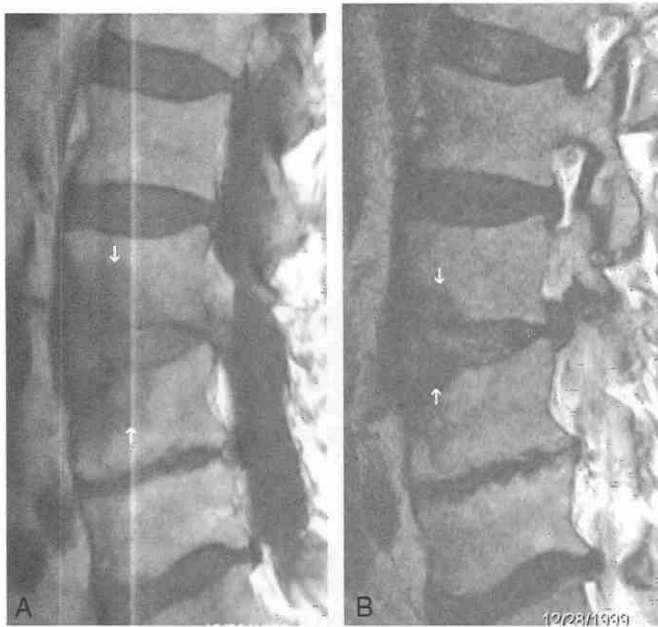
Type III end-plate changes. T1-weighted (A) and T2-weighted (B) MR images show hypointensity of the inferior L3 and superior L4 end plates on both sequences (arrows).
